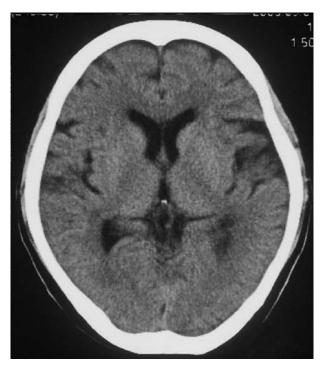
Brain computed tomography (CT) on admission.
